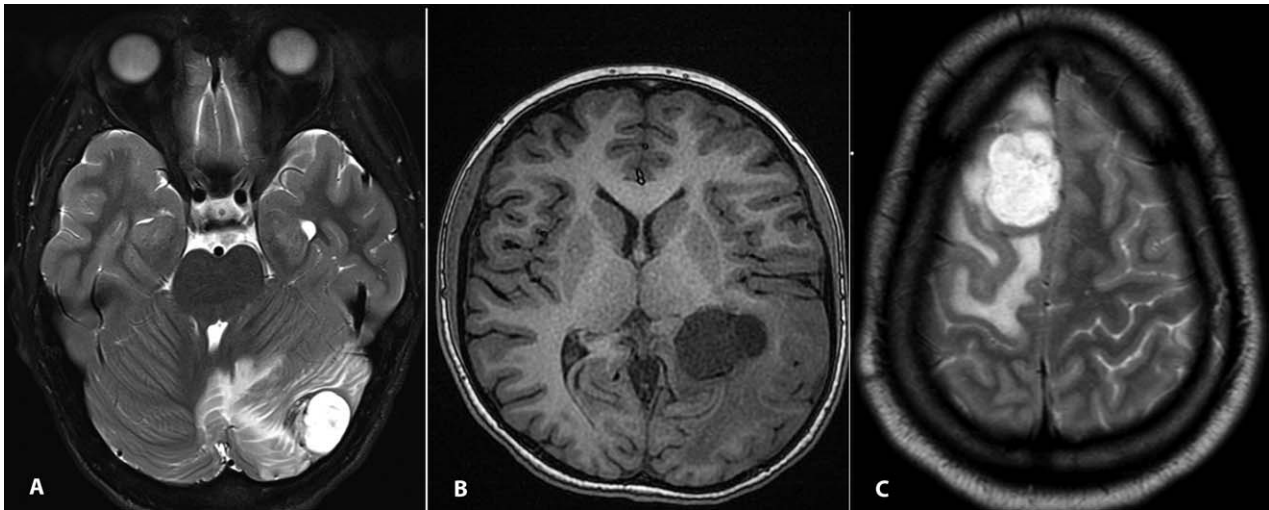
a. Case 1—axial T2-hyperintense well-demarcated tumor in right cerebellar hemisphere with surrounding edema, abutting the dura. b. Axial T1 MRI of case 2 shows well-demarcated tumor
